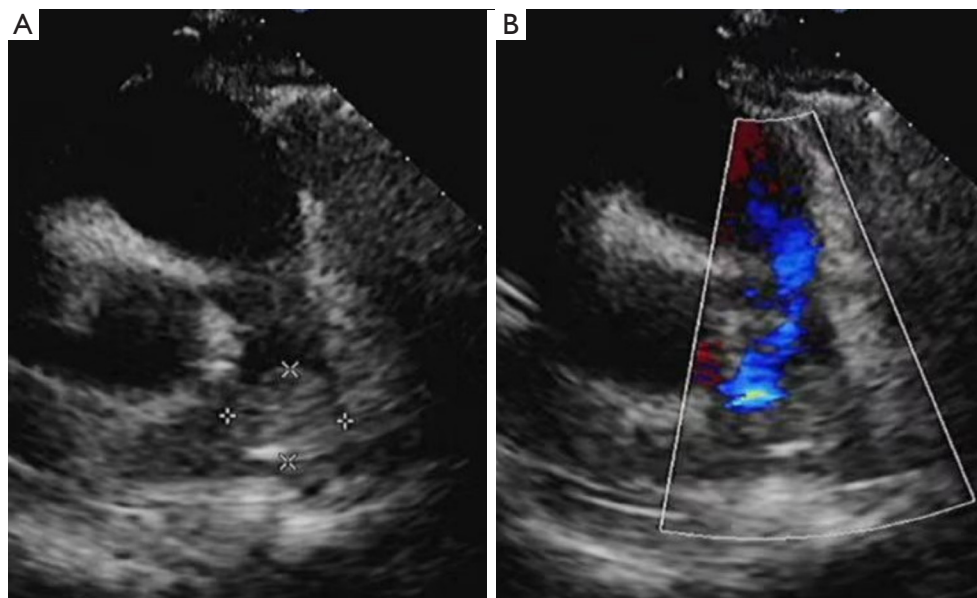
Color Doppler ultrasound. (A) Hypoechoic mass with irregular morphology and heterogeneous internal echogenicity (*) in the pulmonary trunk near the bifurcation of the right and left pulmonary arteries; (B) no significant blood flow signal within the mass, and blood flow in the right and left pulmonary arteries is obstructed.
